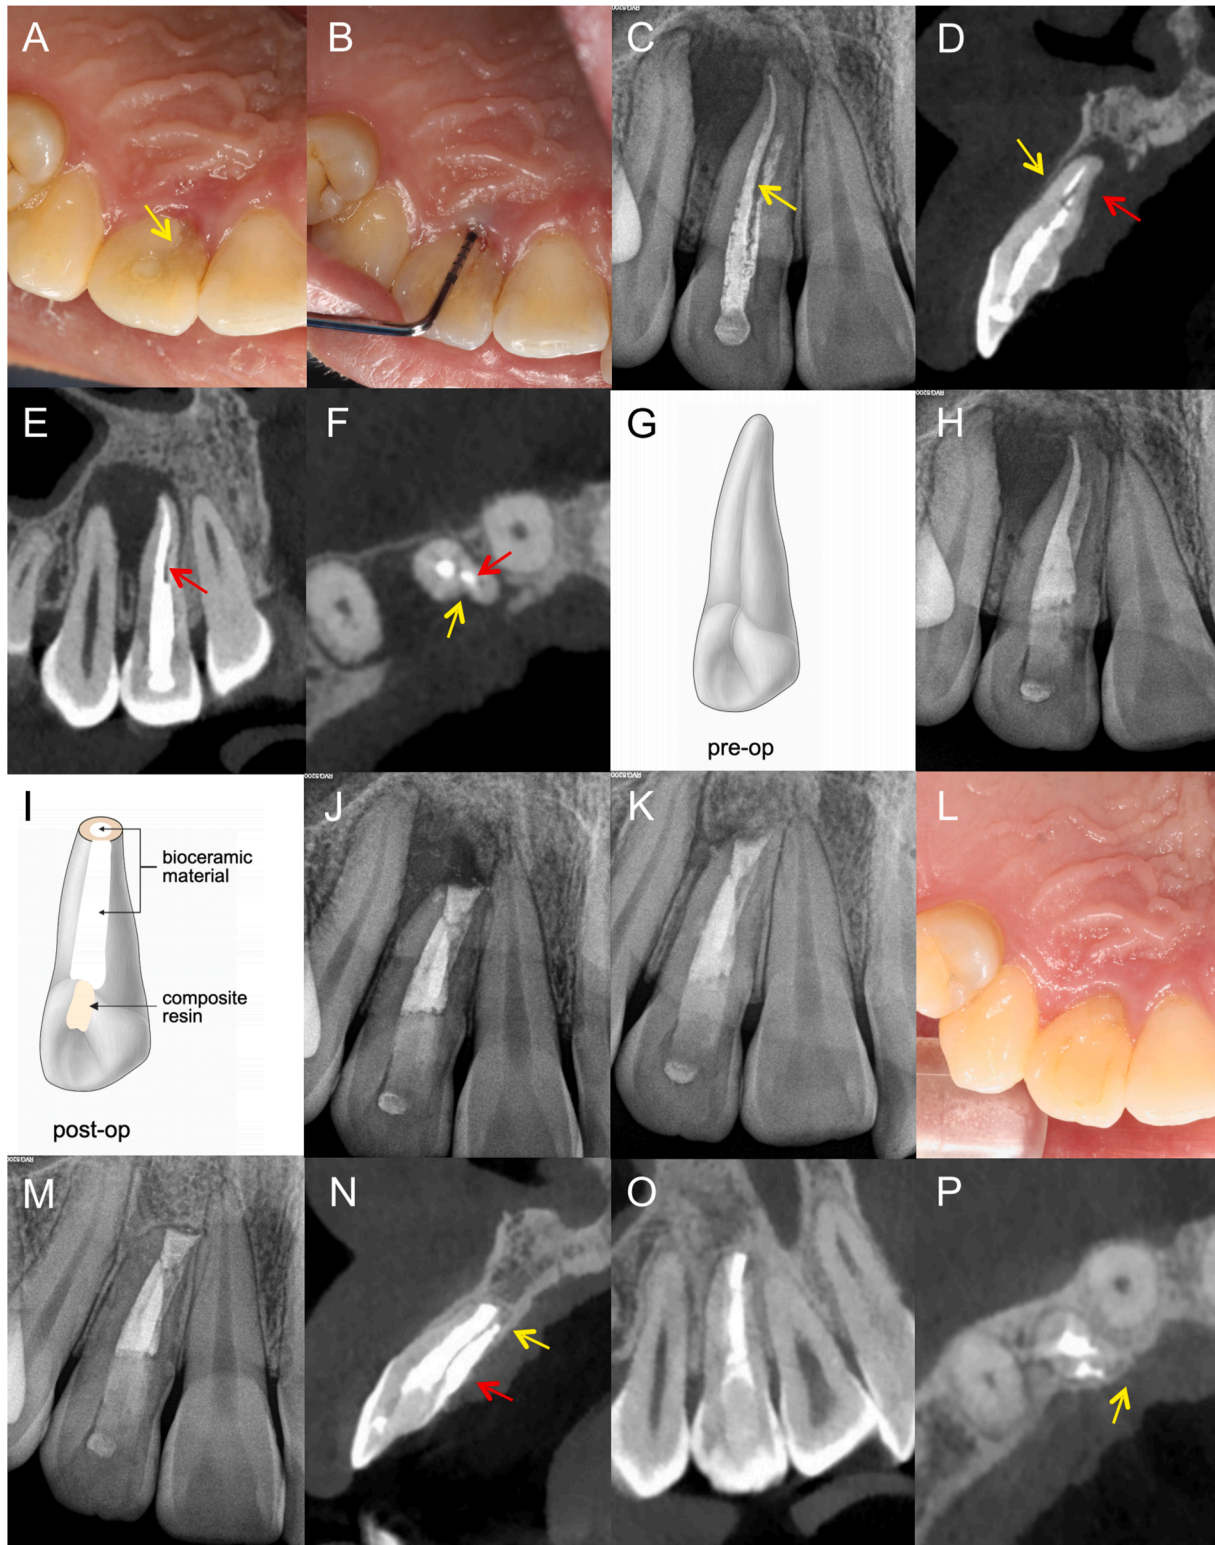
(A) Preoperative intraoral photograph showing gingival redness and swelling at the palatal margin of tooth 12. A developmental groove is evident, originating at the central fossa and crossing the cingulum (yellow arrow). (B) Periodontal probing on the palatal aspect of tooth 12 revealed a depth of approximately 9 mm, with purulent exudate from the gingival sulcus. (C) Preoperative periapical radiograph showing prior root canal treatment of tooth 12, with a radiopaque line on the mesial aspect suggestive of the palatal radicular groove (PRG, yellow arrow) and a large periapical radiolucency. (D) Sagittal cone-beam computed tomography (CBCT) section showing a thin buccal cortical plate (yellow arrow) and complete loss of the palatal cortical plate from the alveolar crest to the apex (red arrow). (E) Coronal CBCT section showing an extensive periapical radiolucency involving tooth 12 and extending distally toward tooth 13, with a gap between the lower root filling and the mesial canal wall
